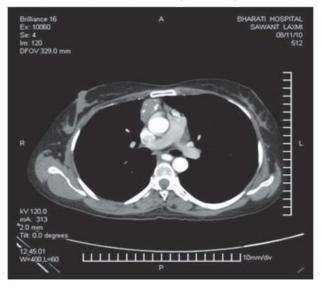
Computed tomography of the chest showing a well-defined mass (arrow) in the anterior mediastinum with peripheral calcification.
